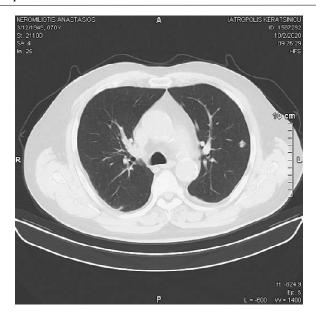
Left upper lobe lesion on the CT Chest
